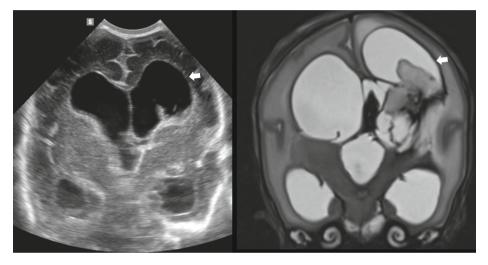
Coronal cUS scan (left) and T2-weighted MRI (right) of a preterm infant with a gestational age of 29 weeks scanned at 34 weeks' postmenstrual age presenting with bilateral grade-3 GMH-IVH. Acute distension of the ventricles persisted >1 week and is therefore referred to as "Post-hemorrhagic ventricular dilatation". PVHI on the left evolved into a large porencephalic cyst (white arrows).
